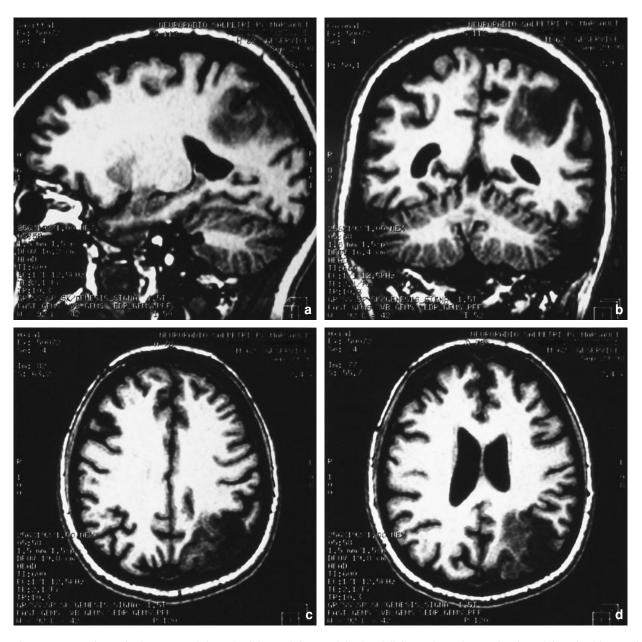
Pre-operative sagittal (a), coronal (b) and axial (c and d) T1-weighted gadolinium-enhanced MRI showing a left parietal low-grade glioma extending to the temporo-parieto-occipital junction, diagnosed in a right-handed woman without any neurological deficit after generalized seizures
